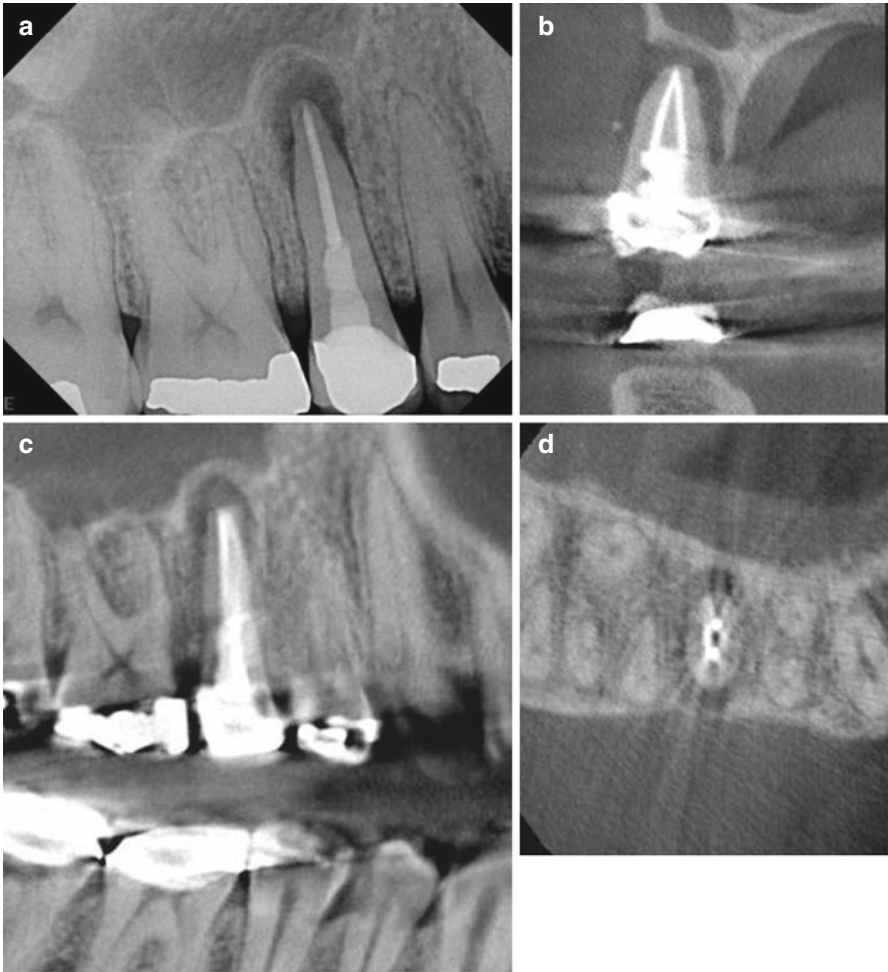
(a–d) A periapical radiograph of a VRF tooth in a maxillary second premolar (a). Note the typical “halo” radiolucency around the root. With CBCT imaging, the radiolucency around the root can be seen in the coronal (b), sagittal (c), and axial (d) images. What can be observed is the bone loss around the root but not the fracture itself (Courtesy Dr. R. Ganik)
